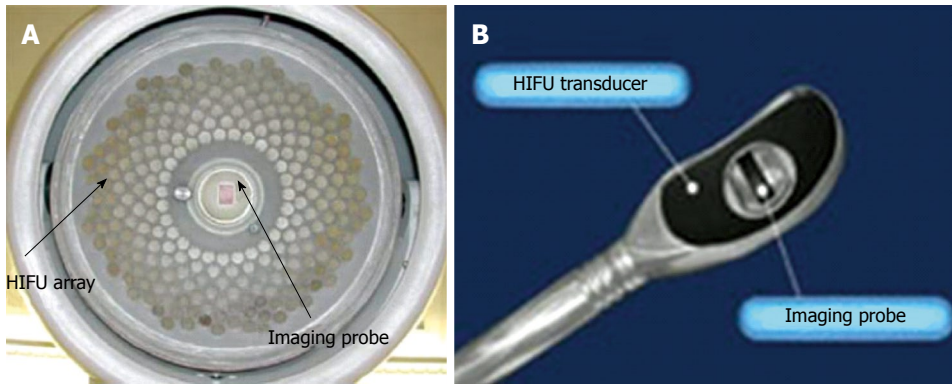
The structure of (A) an extracorporeal (FEP-BY02) and (B) a transrectal (Ablatherm) high intensity focused ultrasound transducer. HIFU: High intensity focused ultrasound.
